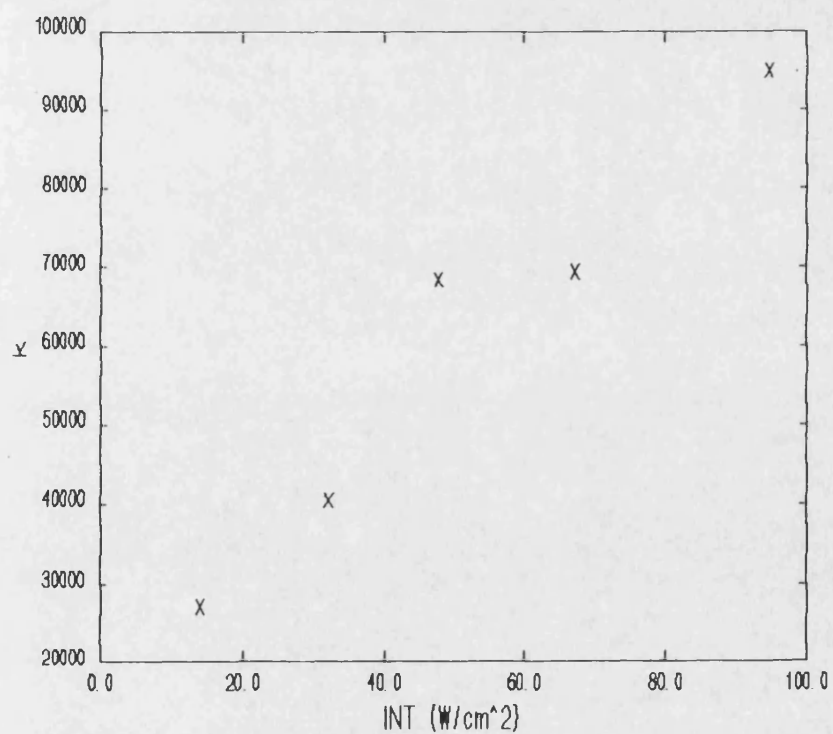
Effect of ultrasonic intensity on the Initial rate constant
